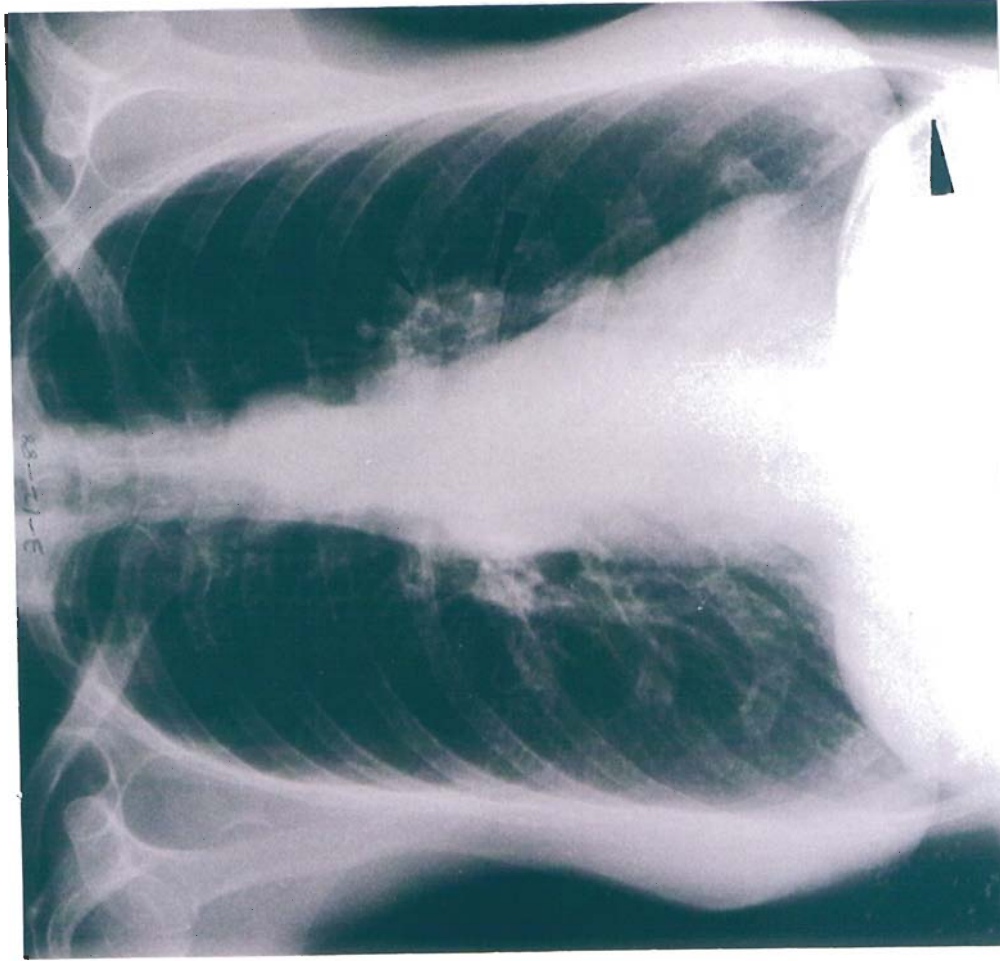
A lady with a left sided pleural effusion and deposits of cancer from a secondary carcinoma of the ovary. Her primary disease had been treated with cytotoxics for approximately 9 months after surgical removal of the ovary itself. She had proven evidence of residual cancer in the peritoneal cavity as well as in the left chest. X-ray taken on 3 December 1988.
